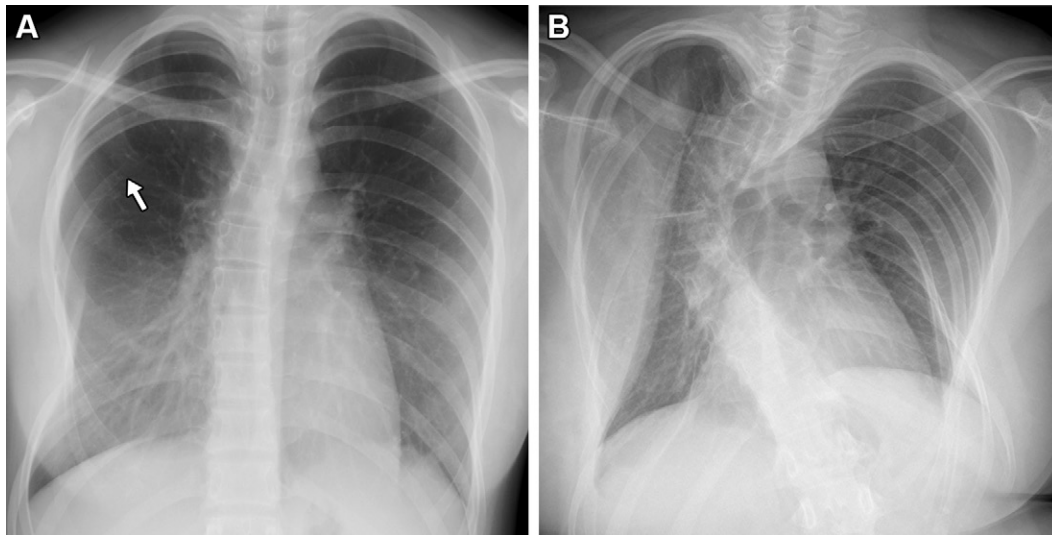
Vanishing ribs in a female patient with Gorham-Stout disease. (A) Frontal chest radiograph at 11 years of age shows thinning and resorption of the posterior right sixth (arrow) to ninth ribs with mild thoracic deformity and scoliosis. (B) Frontal chest radiograph at 21 years of age shows marked progression of rib vanishing, thoracic deformity, and scoliosis.
